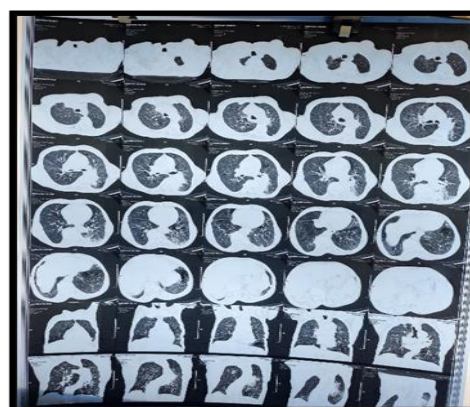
CT chest- restrictive lung disease
